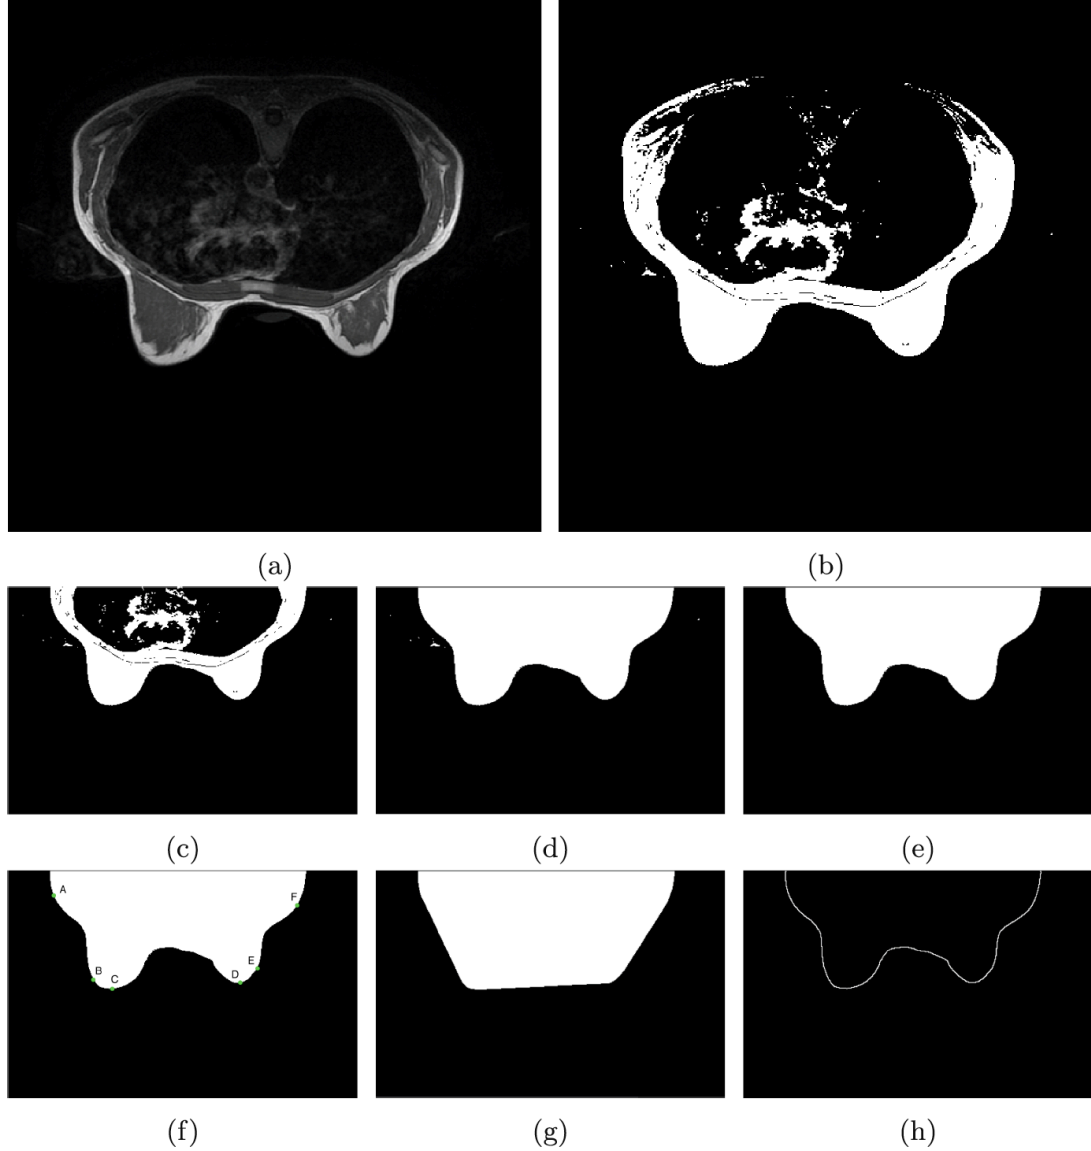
Pre-processing: (a) a breast MRI is loaded; (b) the adaptive thresholding is applied in the MRI to emphasize the contours of the breast; (c) image crop containing the breast regions is considered; (d) the holes are filled in the image obtained in (c); (e) the Largest Connected Component is found in the MRI and all other components are removed; (f) the coordinates of three pairs of green points (A, B, C, D, E, F) are found; (g) the convex hull is computed in the image obtained in Figure e and it is returned a binary convex hull image; (h) the boundary of image obtained in Figure e is extracted with the canny filter.
